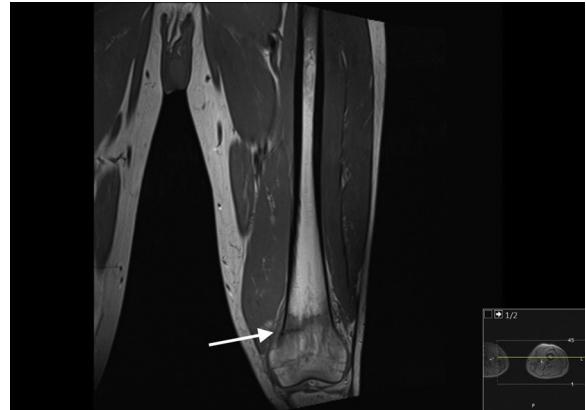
Single cut of MRI demonstrating grade 4 stress fracture of the distal femur.
